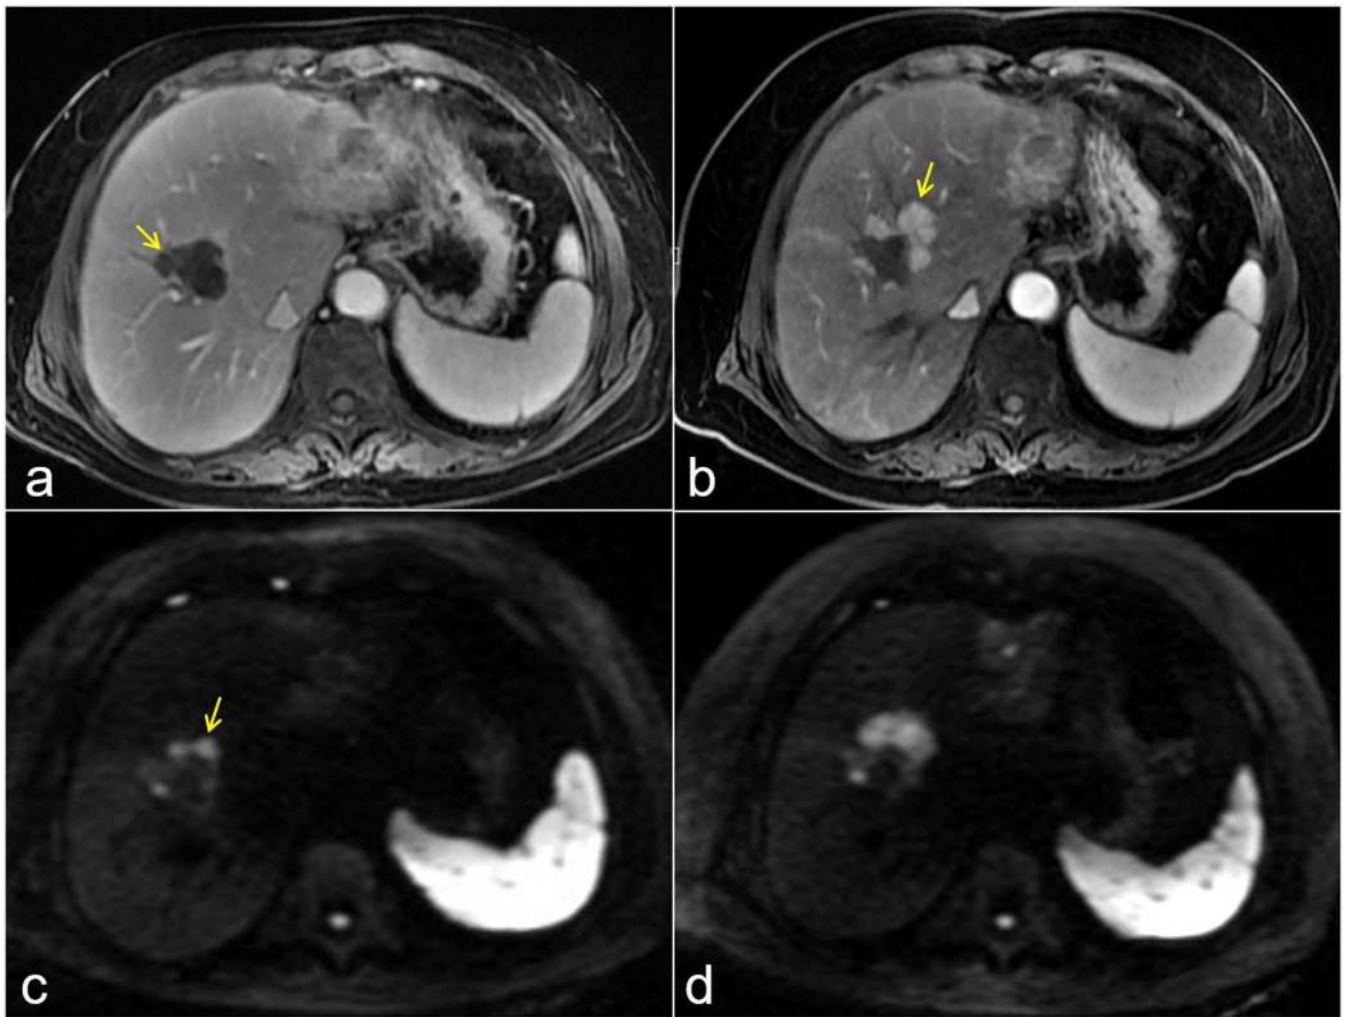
Contrast-enhanced T1W images (top row) and diffusion-weighted images (bottom row) of an HCC patient who received RFA treatment. No obvious enhancement was seen near the post-RFA area (arrow in (a)). However, small recurrent lesions were detected in DWI (arrow in (b)) with much improved contrast. These lesions were confirmed in both contrast-enhanced T1W (c) and diffusion-weighted images (d) at one-month follow-up.
